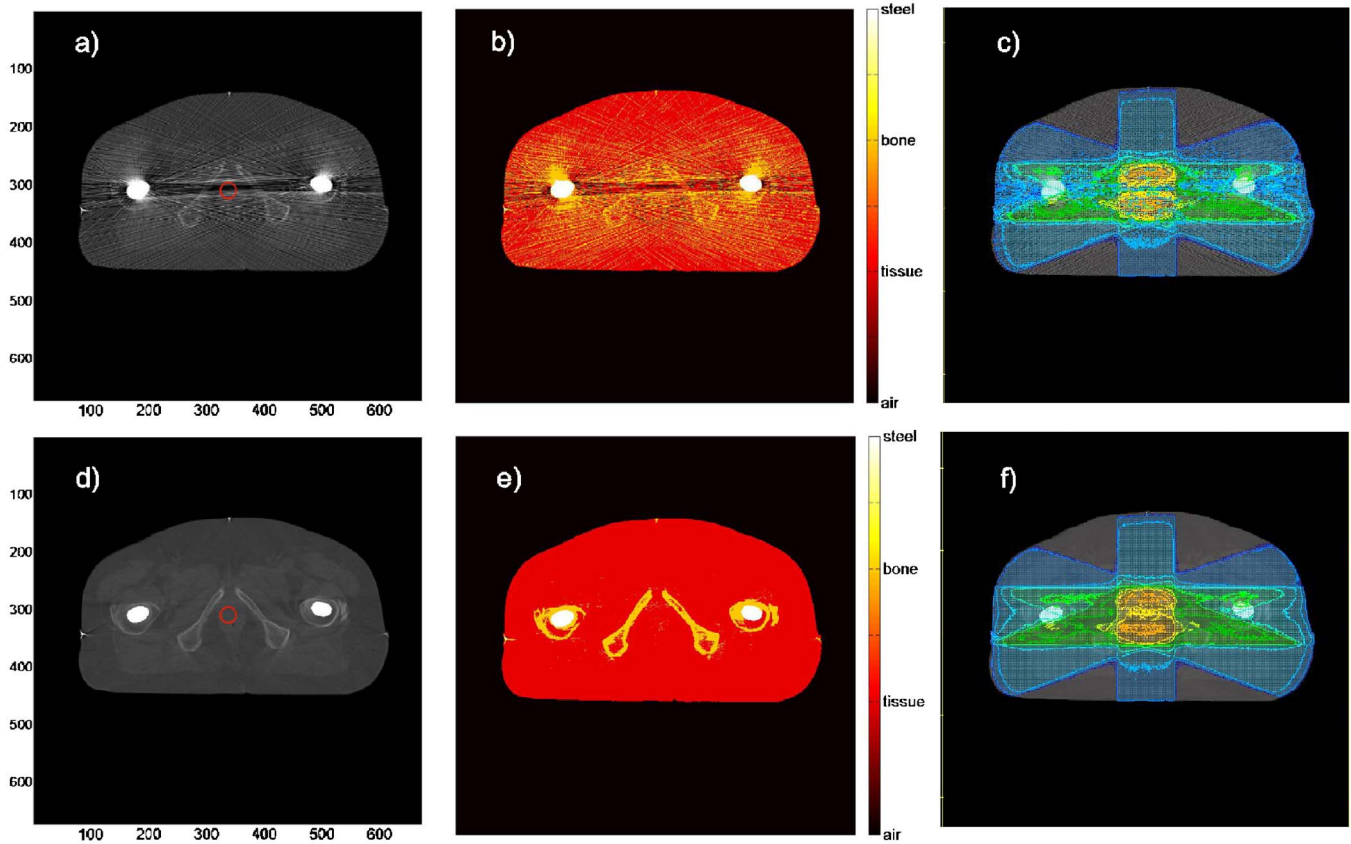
Original CT image (a) and artifact-corrected image (d) of a prostate patient with an ellipsoidal target delineated. Material segmentation in the original CT image (b) and in the artifact-corrected image (e). Dose distribution in five-field 18 MV photon beam setup in the original CT image (c) and the artifact-corrected image (f).
